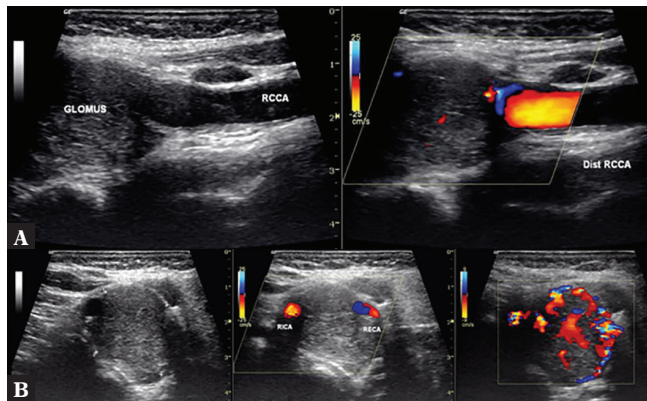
A. Horizontal sections: A hypoechoic well-delineated borders nodule of compound structure at the peripheral section of the common carotid artery. B. Vertical sections: A distinct lesion measuring 28 × 24 mm, causing dilatation of the internal and external carotid arteries in their course. Increased vascularity with the use of color Doppler from external carotid branches in their course
